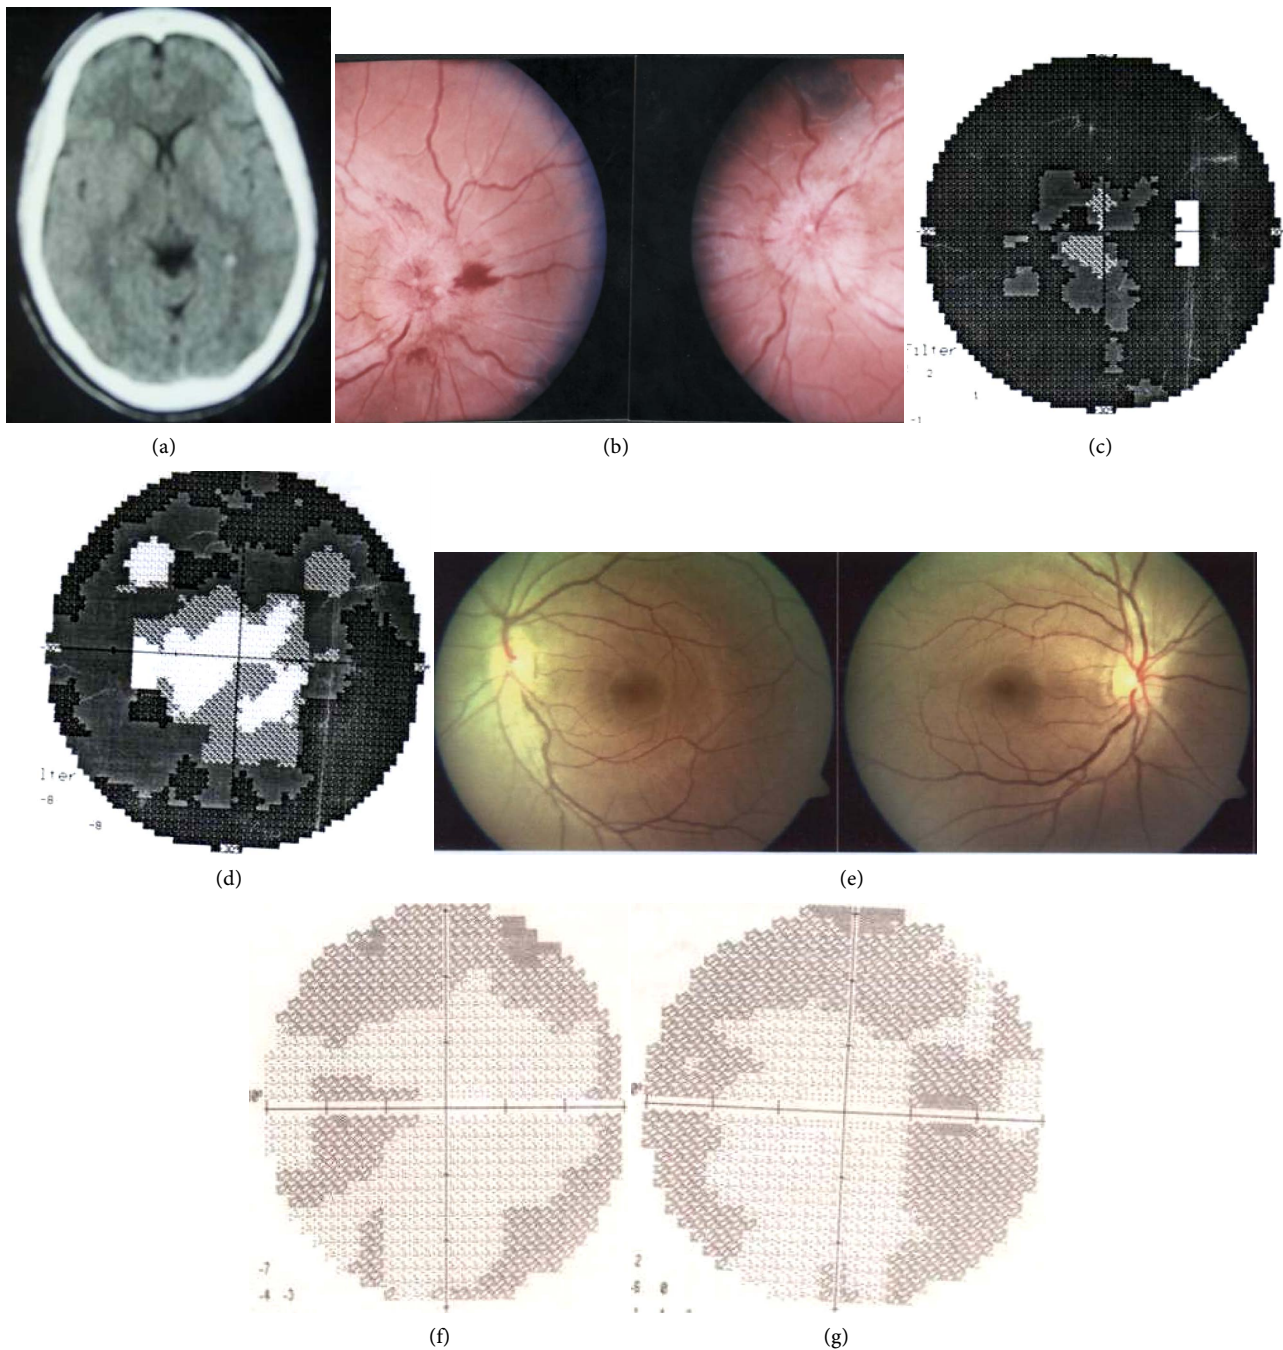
Female patient with lumboperitoneal shunt, (a) Preoperative Axial normal CT brain of the patient, (b) Preoperative fundus examination showed advanced papilledema, (c) Preoperative Visual field of the patient showed concentric contraction of the field in the left eye, (d) Preoperative Visual field of the patient showed tubular field of the right eye, (e) Postoperative fundus examination showed complete resolution of papilledema, (f) and (g) postoperative visual field showed bilateral improvement of the field.
